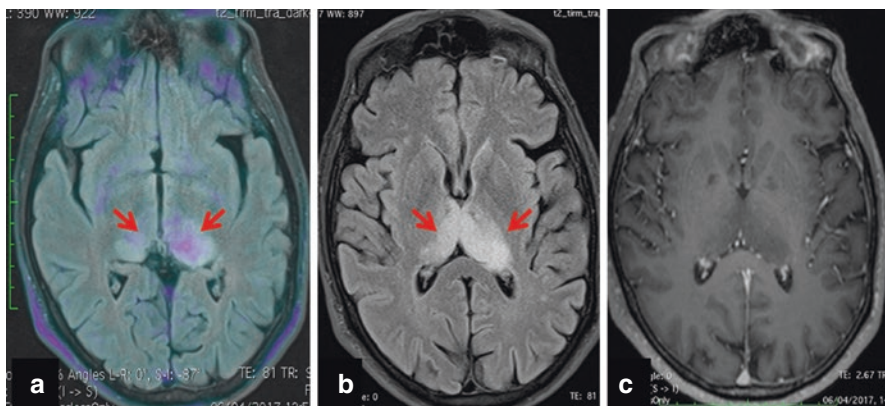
(a–c) Axial fused ^{18}F DOPA PET/MR (a), axial T2W FLAIR (b) and axial post-contrast T1WI (c) show bilateral increased ^{18}F DOPA tracer uptake in the thalami (left > right) (a, arrows) with corresponding high-signal changes (b, arrows) and no significant enhancement on the post-contrast image (c). The left thalamic lesion was proven upon biopsy to be a low-grade tumour with transformation into high-grade glioma.
